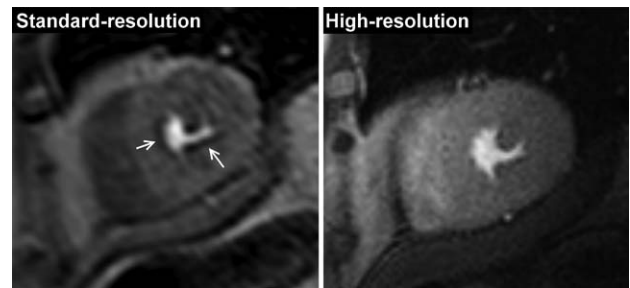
Dark-rim artifact. A 60-year-old man with suspected angina underwent stress perfusion cardiovascular magnetic resonance at 1.5 T with both standard-resolution (2.5 mm in-plane) and high-resolution (1.5 mm in-plane) acquisition. High-resolution acquisition was facilitated by 8-fold *k*-t broad linear speed-up technique acceleration. There were no significant stress-induced perfusion defects seen with either acquisition (mid-ventricular slices shown), but there was significant dark-rim artifact on the standard-resolution images (arrows). Subsequent x-ray angiography confirmed normal coronary arteries.
